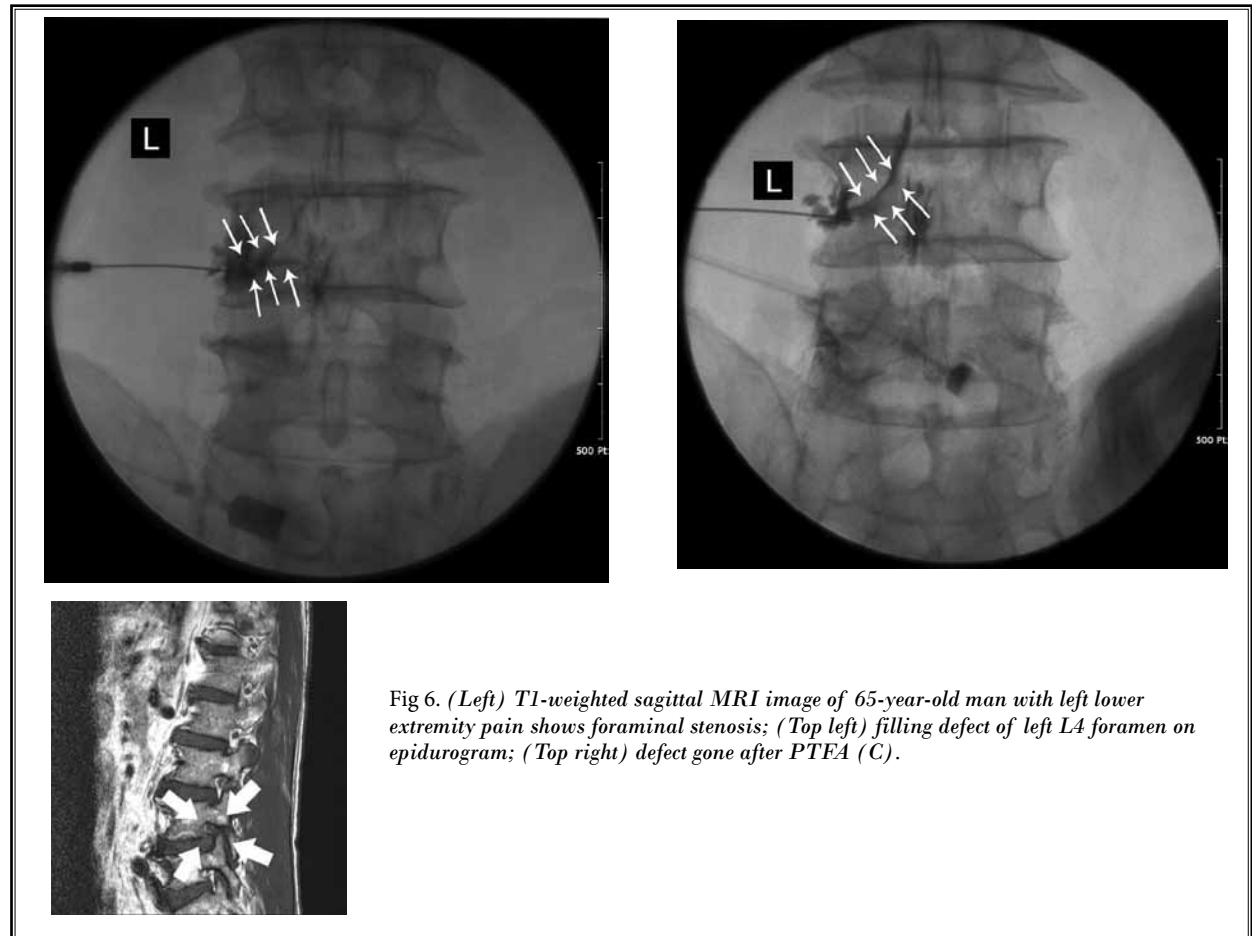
(Left) T1-weighted sagittal MRI image of 65-year-old man with left lower extremity pain shows foraminal stenosis; (Top left) filling defect of left L4 foramen on epidurogram; (Top right) defect gone after PTEA (C).
